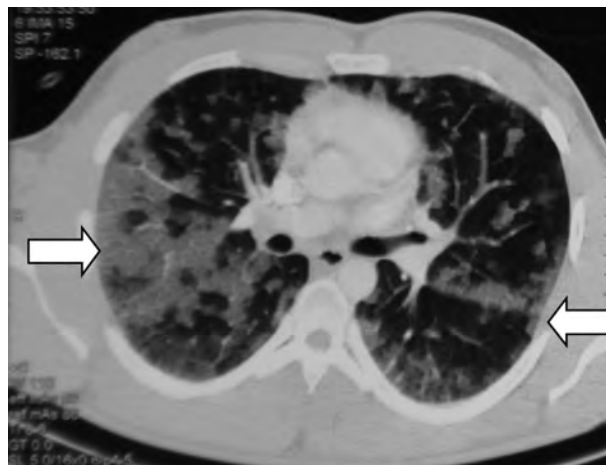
Chest computed tomography showing increased density in ground glass opacities, bilateral, predominantly sub-pleural and in the lower lobes, associated with septal thickening (arrows).
